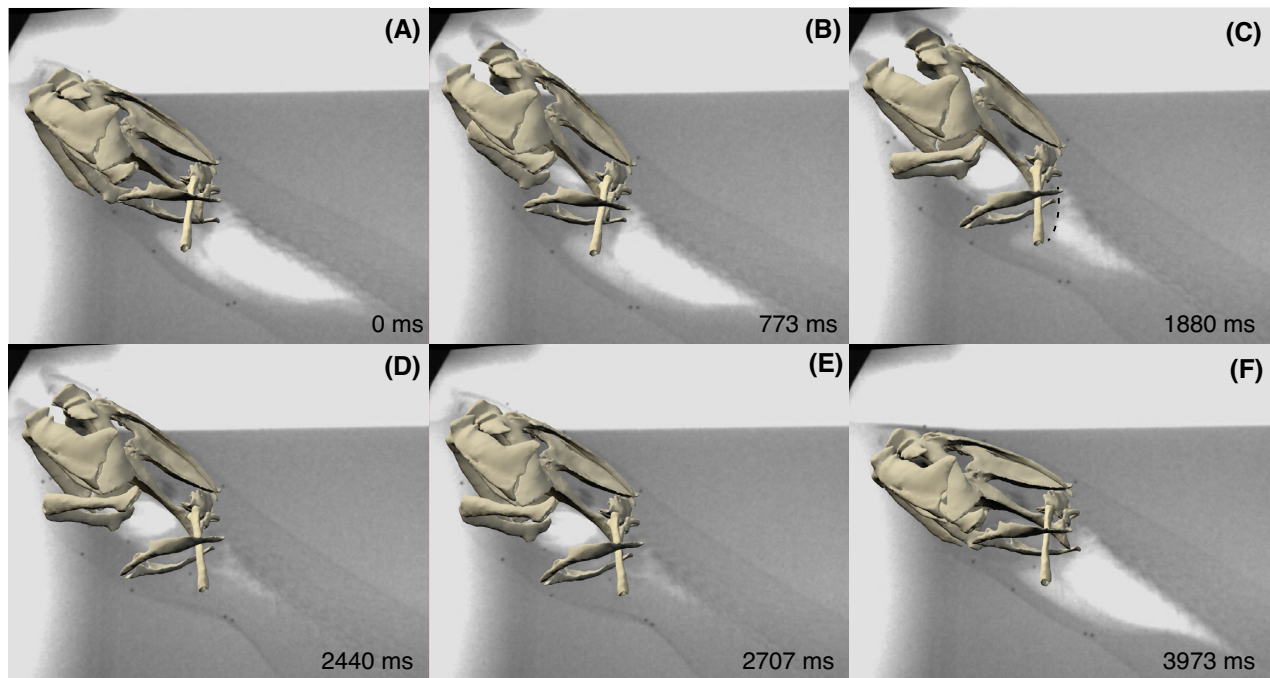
A series of frames from an X-ray video and XROMM animation of a lungfish breathing air. (A) Start of the breath, defined as the start of lower jaw depression. (B) Start of lung deflation. (C) Peak ceratohyal depression. The dashed line indicates the shadow of the retractor costalis, which can also be seen in the other frames. (D) End of lung deflation. (E) Start of lung inflation. (F) End of lung inflation. See Fig. 1 for identification of the skeletal elements.
